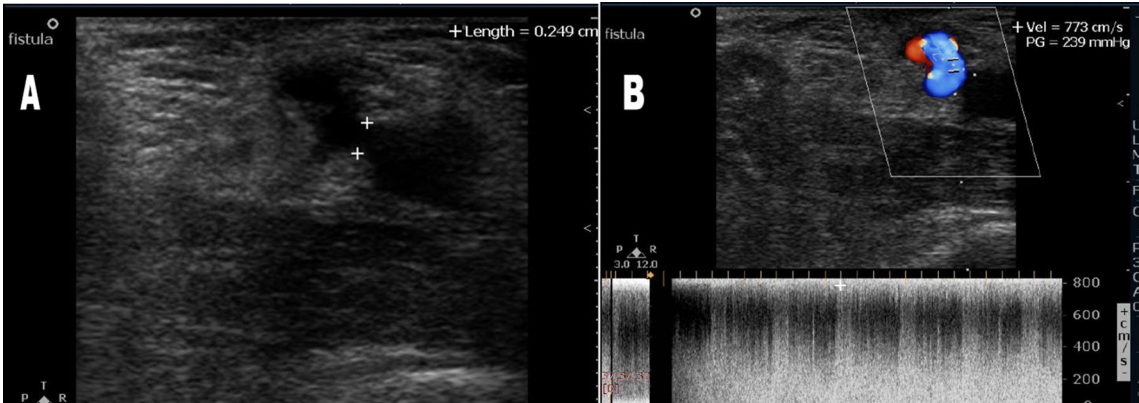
Fistula stenosis. A Sonographic examination of the fistula revealed reduced diameter (0.249 cm). B Color Doppler examination of the fistula showed high PSV 773 cm/s
